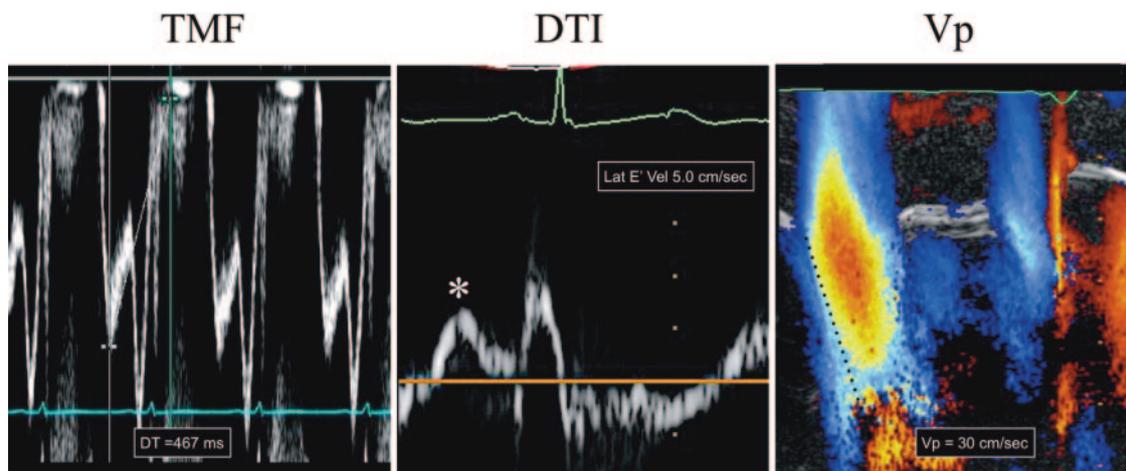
Indirect measures of left ventricular (LV) relaxation. Transmitral flow (TMF) demonstrating a typical impaired relaxation pattern E/A < 1 and deceleration time (DT) > 220 milliseconds. Impaired relaxation is the earliest abnormality and present in most patients with diastolic dysfunction. E' velocity < 8 cm/s is consistent with the diagnosis of diastolic dysfunction and is more sensitive than the pulse wave Doppler-derived TMF. Flow propagation velocity (Vp) correlates with the rate of myocardial relaxation. It can be normal despite impaired relaxation, particularly in patients with normal ejection fractions and LV volumes. DTI = Doppler tissue imaging.
